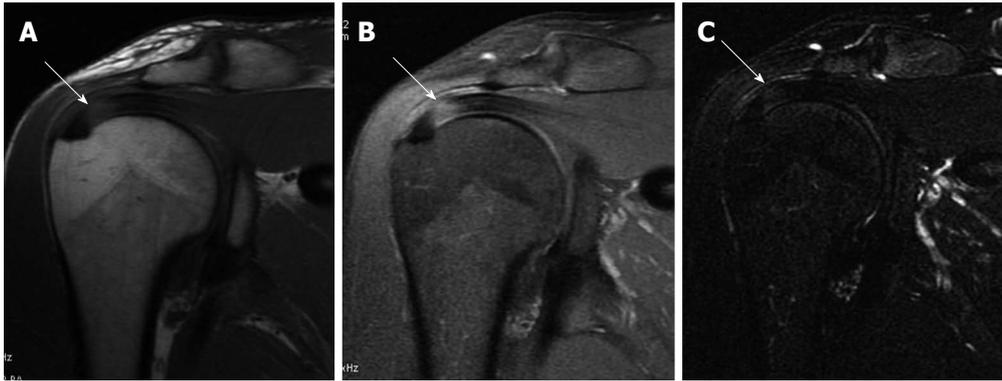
Supraspinatus tendinosis. A: Coronal oblique T1-weighted image. B: Coronal oblique fat-sat proton-density image. Images (A) and (B) show focal high signal intensity within the distal supraspinatus tendon (arrow); C: Coronal oblique fat-sat T2-weighted image shows focal high signal at the same site within supraspinatus tendon (arrow). Final diagnosis was tendinosis.
